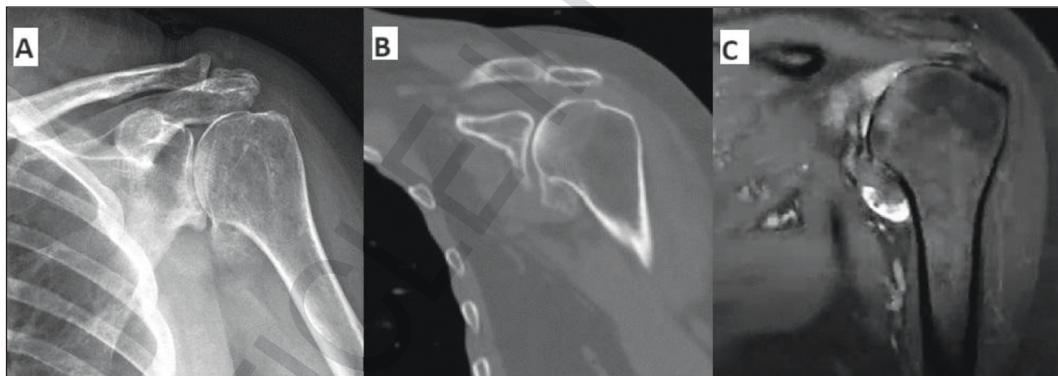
A) Anterior-posterior X-ray imaging of the left shoulder showed a mass originating from the medial part of the anatomical neck of the humerus. B) The coronal computed tomographic scan shows the intraarticular osteochondroma along the medial aspect of the anatomical neck of humerus. C) The coronal magnetic resonance imaging demonstrated cortical and medullary continuity between the lesion and the humerus.
